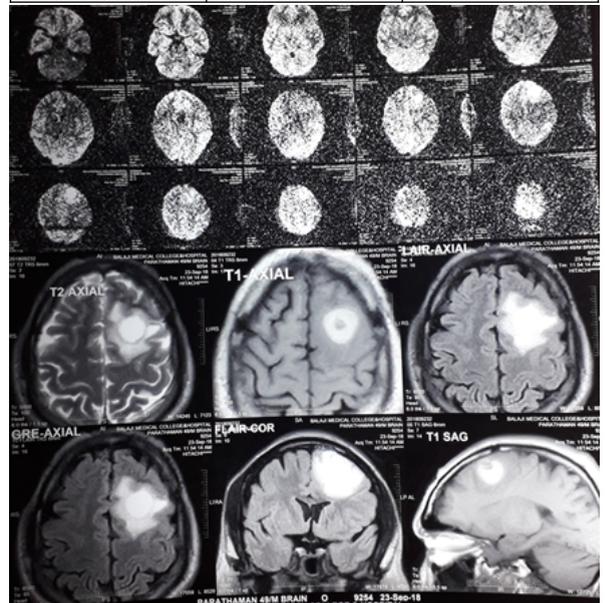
1 shows MRI brain shows a well defined spherical T2 hyperintense mass lesion approx 2.4*2.3*2.1cm occupying the left superior frontal region with significant perilesional edema with small T1 hypointense component approx 7*7mm noted within the lesion.
